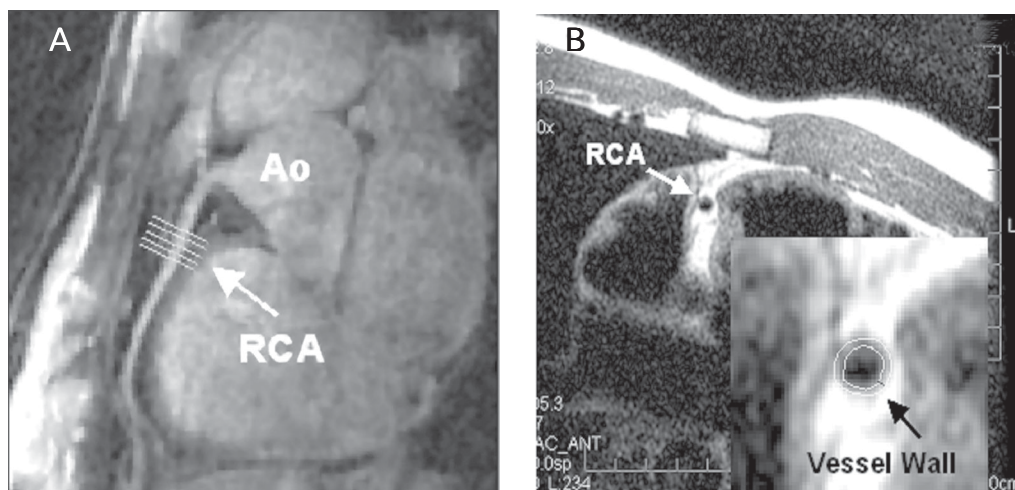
Magnetic resonance imaging (MRI) of a 26-year-old healthy male subject. Double-oblique view of the right coronary artery (A) with transverse prescription and cross-sectional black-blood magnetic resonance images of circular lumen and thin wall in magnified view (B). Ao = aorta; RCA = right coronary artery.
